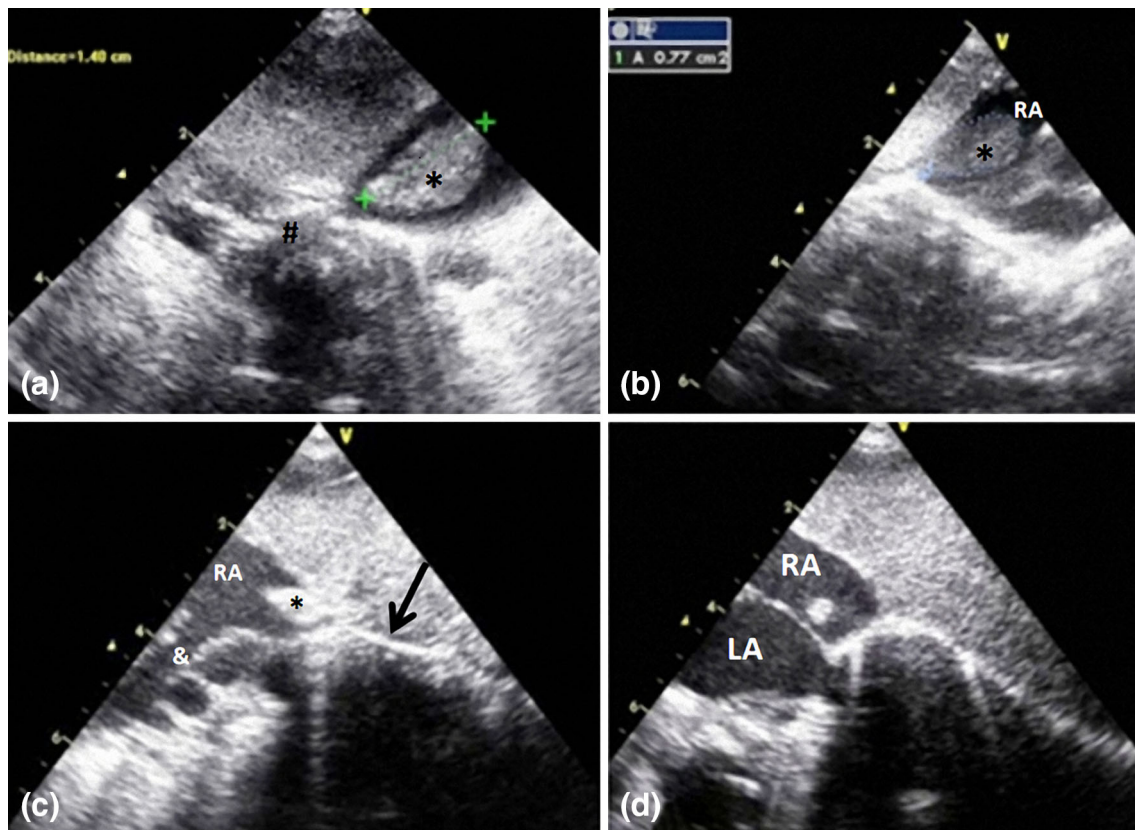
The mass was monitored with serial follow-up transthoracic echocardiography in subcostal views. Echocardiogram showed the floating, oval thrombus sized 14×8 mm in diameter (large enough to half fill the right atrium) thrombus in 7th days of admission (a), The thrombus was seen to get smaller 1 week after initiation of iv heparin treatment (b), it was appeared gradually became smaller
